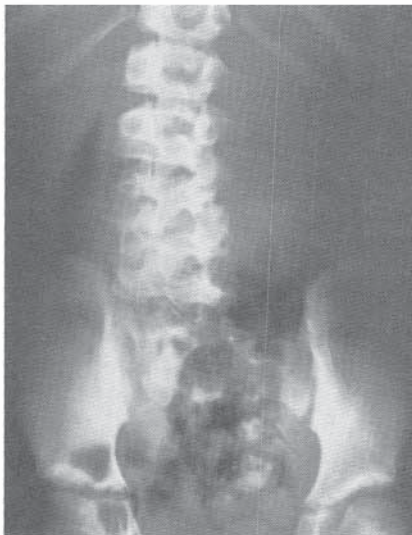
Type I lumbosacral agenesis (in the Renshaw classification). The right hemisacrum is absent, evident on the anteroposterior radiograph. (From Renshaw TS: Sacral agenesis. *J Bone Joint Surg* 1978;60-A:373.)
